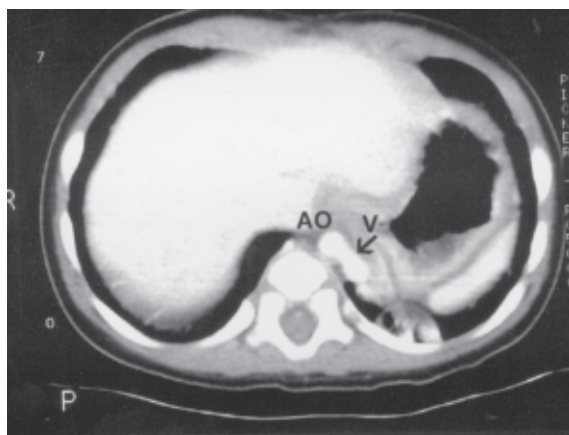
Enhanced axial CT scan of case 5 shows the infra-diaphragmatic blood supply to the sequestered lung.
